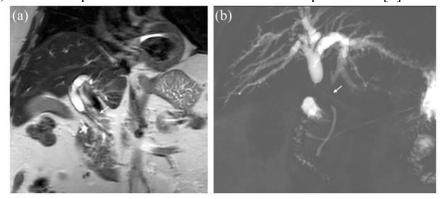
A 74-year-old man with cholestasis, loss of weight, and increased CA19-9 serum level (190 U/l, normal values <37 U/l). Coronal MR T2-weighted image (A) and 2D-MRCP (B) show a long common bile duct stricture with upstream dilatation and no mass. After a 2-week negative steroid trial, the patient underwent surgery and pathological analysis revealed a T2N0 cholangiocarcinoma [1].
